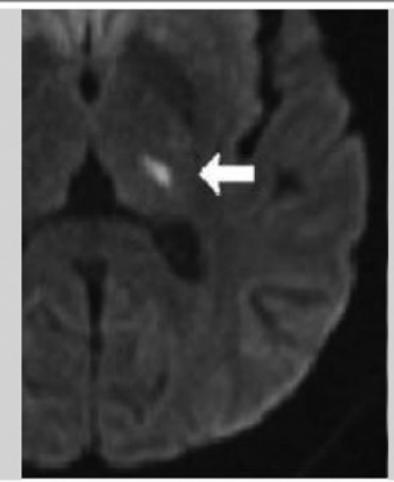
Variable fates of lesions related to small vessel disease and the convergence of acute lesions with different causes but similar late appearances on MRI
